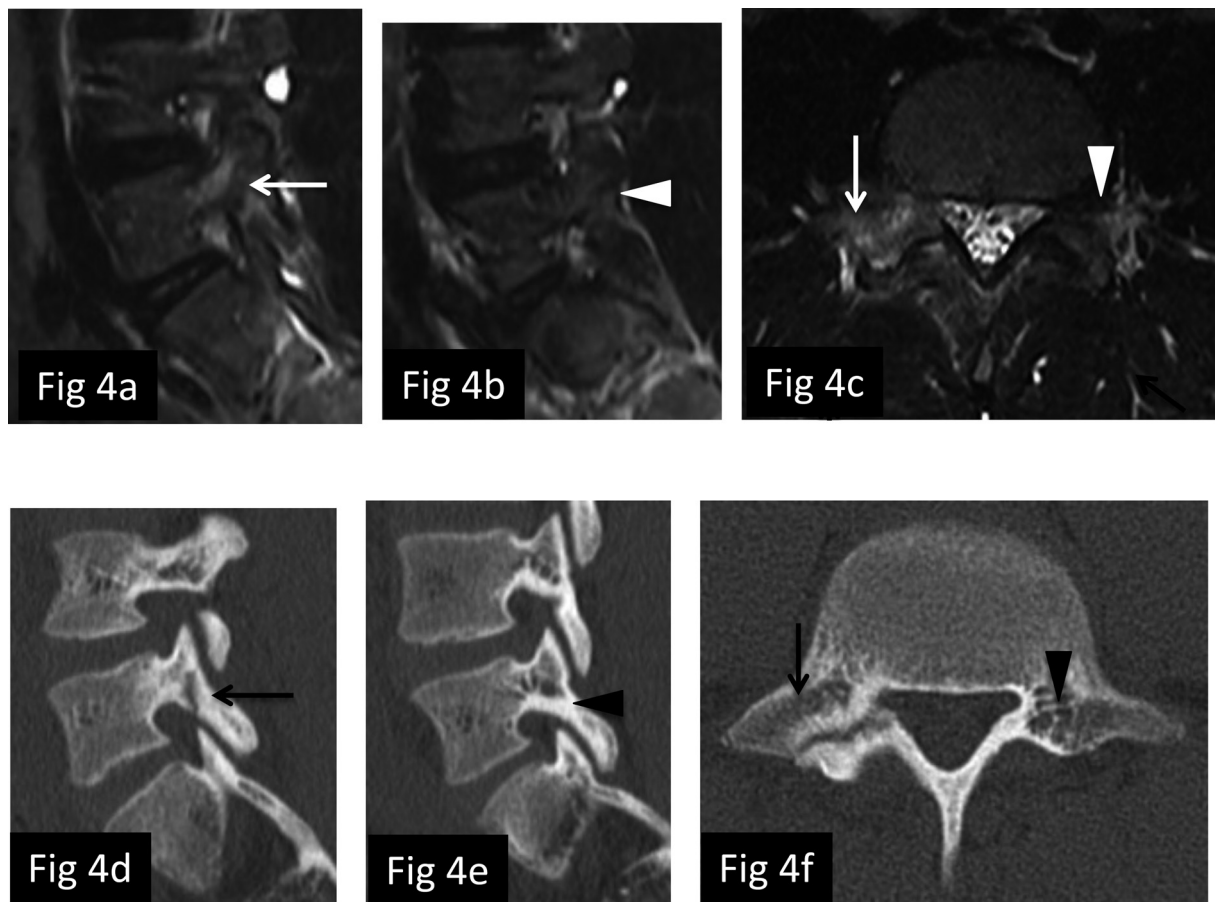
Case 2 at his first visit to the hospital. a–c) MRI STIR showed bone marrow edema on the right side only, around the pedicle (white arrow), and was normal on the left side (white arrowhead). d–f) CT showed an incomplete bony cleft on the right side (black arrow) and was normal on the left side (black arrowhead). MRI STIR, magnetic resonance imaging short-tau inversion recovery; CT, computed tomography. (a and d: sagittal slices on the right, b and e: sagittal slices on the left, and c and f: axial slices on L5.)
